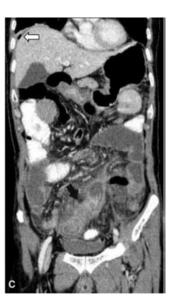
Axial (a), sagittal (b) and coronal (c) views of contrast-enhanced CT scan of the abdomen and pelvis. There is an intussuscepted distal small bowel (black arrow) with an intraluminal mass (asterisk), causing proximal obstruction and dilatation. Note the presence of air under diaphragm representing pneumoperitoneum (white arrow).
